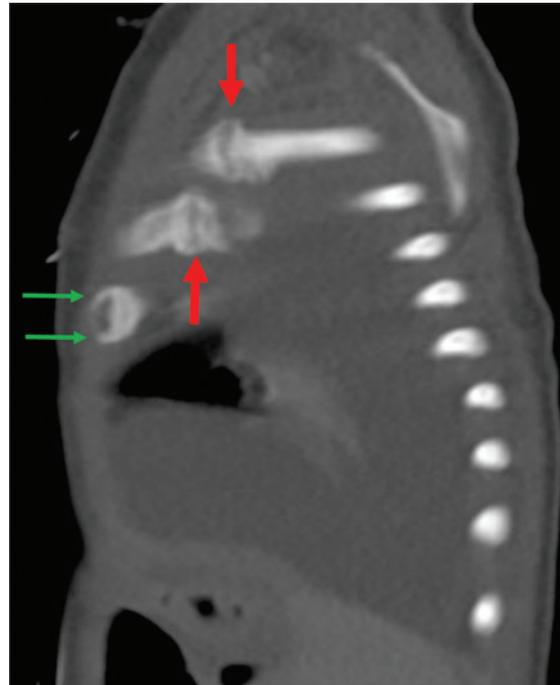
(Case 6) This figure is a lateral chest X-ray at 5 weeks of age that shows two ribs that are cupped and flared (red arrows) with perichondrial spurs (green arrows) at the costochondral junction, consistent with a rachitic rosary.
